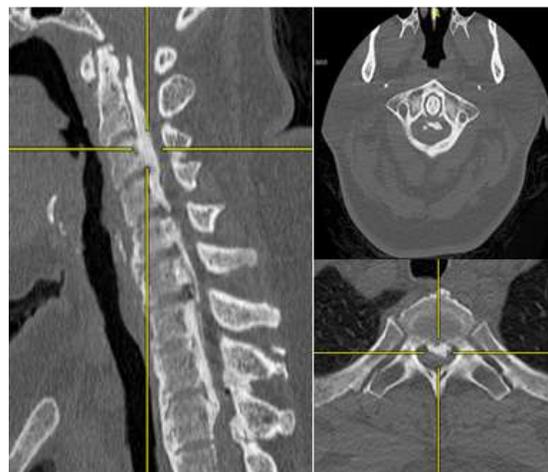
CT cervical revealed extensive continuous cervical OPLL from cervical C1 to thoracic T2.
